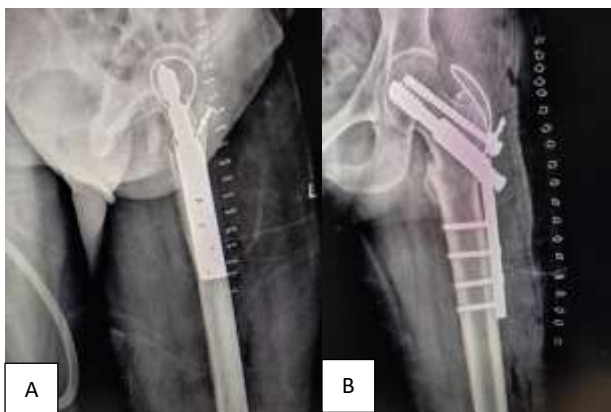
(A and B): Post operative x-rays.
